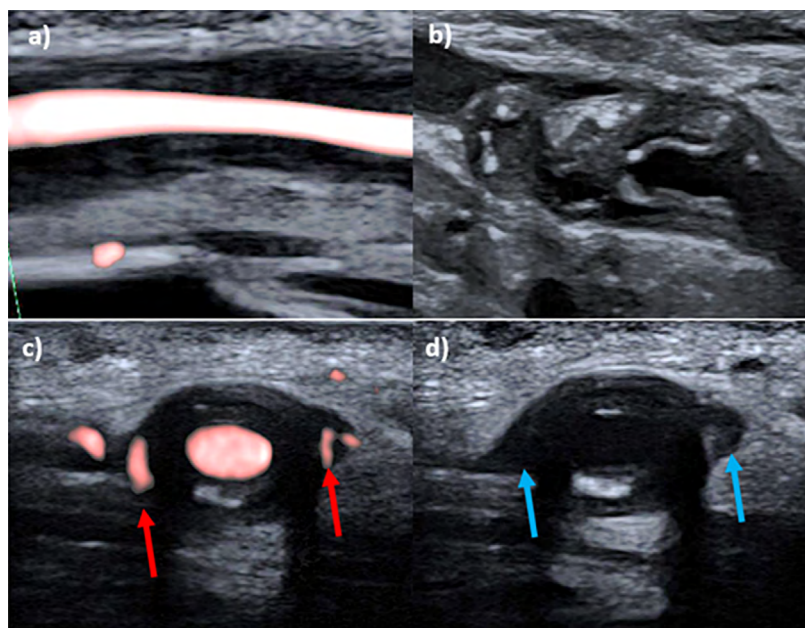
Ultrasound images of GCA affected temporal arteries. a) Low-medium echogenic walls b) Mixed echogenic walls c) Neovascularization (red arrows) d) Swelling outside the vessel walls (blue arrows).
